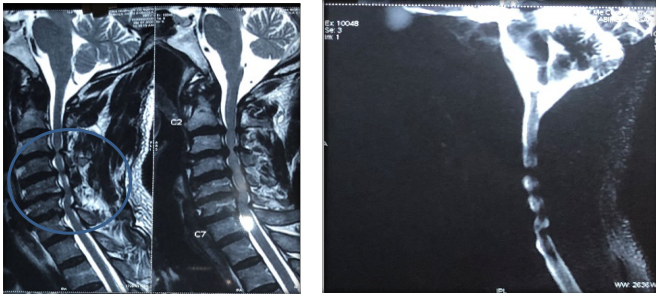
Shows pre-operative T2 weighted MRI Imaging study of the Cervical Vertebrae showing severe narrowing of the spinal cord at C2/C3, C4/C5, C5 /C6 levels. D : T2 weighted image of the cervical vertebrae showing complete multilevel obliteration of the spinal cord cerebrospinal fluid in the cervical vertebrae.
